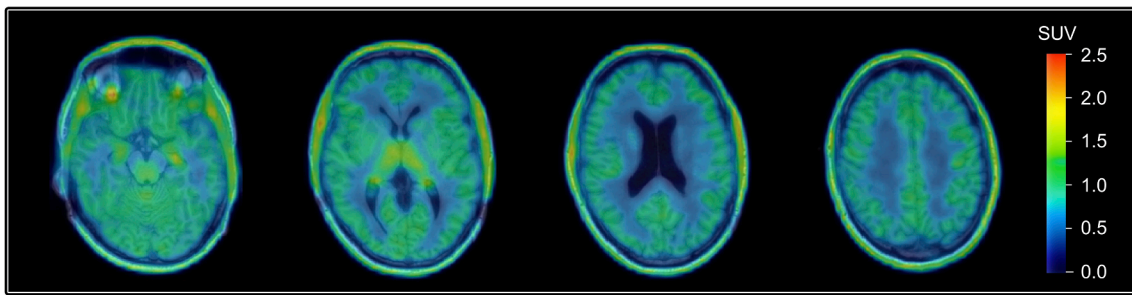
Transverse slides from the first baseline scan showing diffuse uptake of ¹⁸F-DPA-714 throughout the brain. Merged PET and T1 MR images from a representative subject SUV: standardized uptake value averaged for the final 30 minutes.
